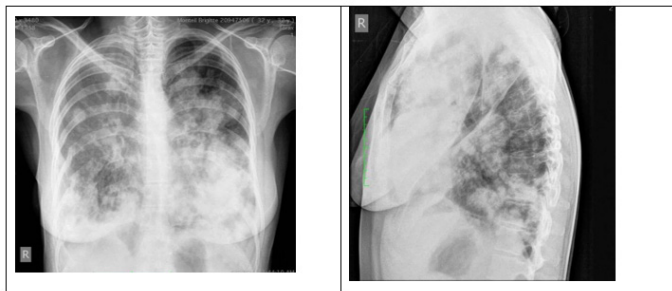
On August 6, 2024, a PA and Lateral Chest X-Ray was Obtained Showing Multiple Radiopaque Images, Nodular in Appearance, with Irregular, Partially Defined Edges, Varying In Size, With Larger Images Observed in the Left Lung Field, Diffusely Distributed Bilaterally, predominantly in the Lower Lobes.
